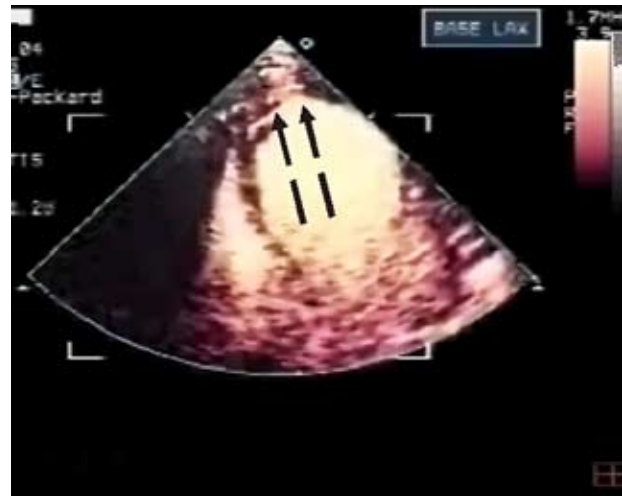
Myocardial contrast echocardiography images (myocardial perfusion) in the apical four-chamber view. The arrows show the contrast extrusion from the left ventricular cavity into the myocardium in the apex, suggesting an impending rupture.
